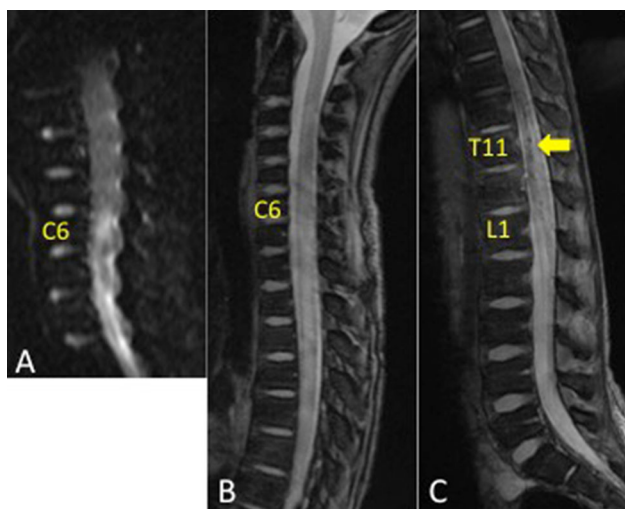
Magnetic resonance images (MRI) of 1 week after trauma (a) and 2 weeks after trauma (b, c). Diffuse weighted MRI (a) shows increased signal below C6 vertebral level. T2 star-weighted sequence shows minor bleeding at T11 vertebral level (arrow) and increased signal within spinal cord below C6
